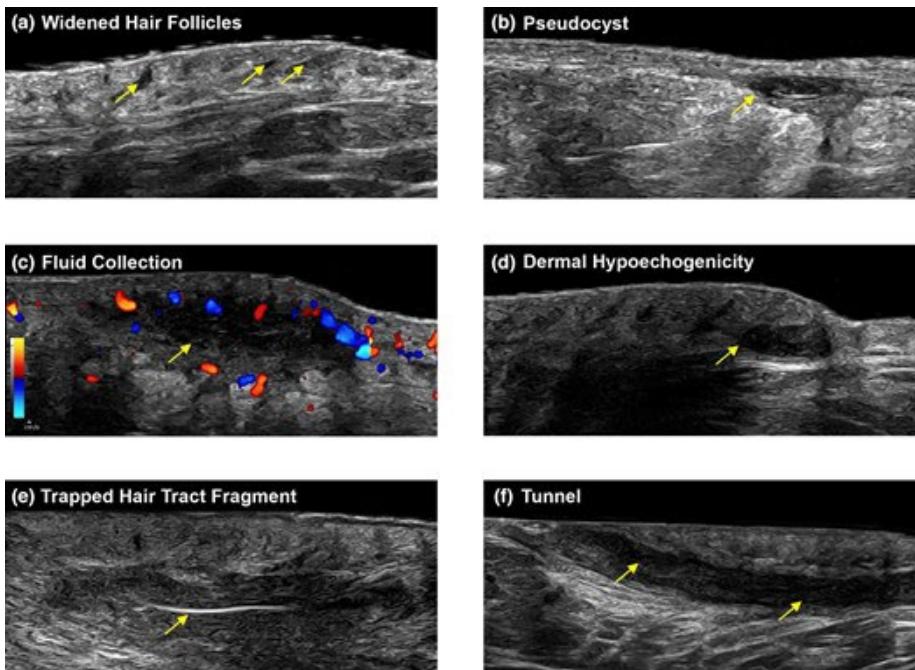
Lesional features according to the sonographic scoring for hidradenitis suppurativa (SOS-HS) criteria. Arrows highlight the feature(s) of interest. The widening of a hair follicle (a) can cause it to rupture, allowing fluid to enter the resulting hypoechoic cavity, leading to the formation of a pseudocyst (b). As more fluid accumulates in the cavity, an anechoic fluid collection (c) can form. Colour Doppler sonography detects a high concentration of vessels at the periphery, indicating inflammation. Dermal hypoechoogenicity (d) occurs due to edema. Ectopic hair tract fragments (e) may provide a scaffold for the formation of tunnels (f), which are horizontal, permeable channels that connect multiple suppurative cavities or skin openings. *Br J Dermatol*, Volume 188, Issue 5, May 2023, Pages 591–600, <https://doi.org/10.1093/bjd/ljad028>
